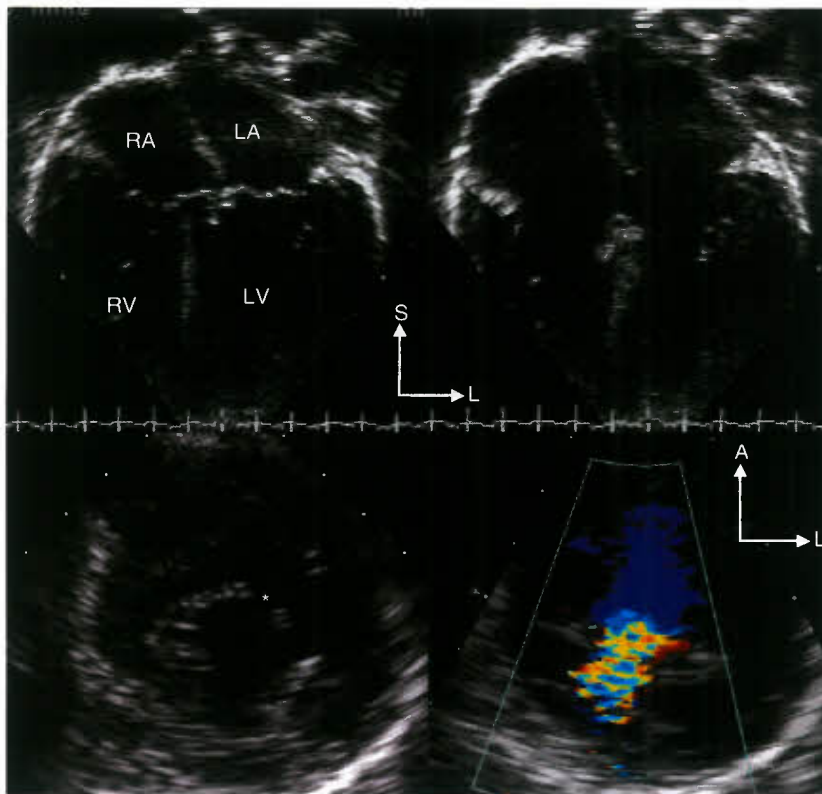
Partial AVSD: AV valve anatomy. Top left: Systolic apical four-chamber image demonstrating that both right and left AV valves insert onto the crest of the ventricular septum at the same level. Top right: Corresponding diastolic frame showing a large primum ASD. Systolic frames often understate the size of the interatrial communication. There is significant RA and RV enlargement. Bottom panels: These are parasternal short-axis scans focused at the valve leaflet level in the left ventricular inflow. The left panel demonstrates the cleft in the anterior leaflet of the left AV valve (*asterisk*). The anterior leaflet is made of two separate components that move independently. This creates the diastolic gap in the leaflet (*asterisk*). Color Doppler on the right panel shows considerable regurgitation through the cleft. LA, left atrium; LV, left ventricle.
